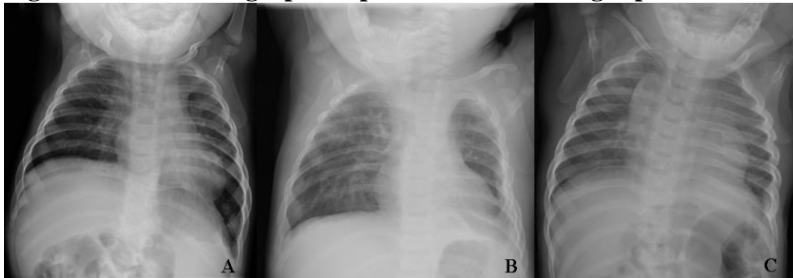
Chest radiographs of patients 1-3 following repair of CDH.
